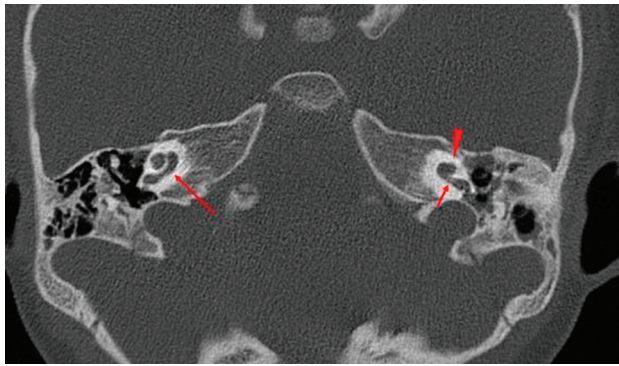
CT image of the patient with *SIX1*-BOR in whom the right cochlea does not demonstrate any offset (*long arrow*), while the left cochlea has an offset but with an appearance akin to cochlear hypoplasia type 4 rather than the typical unwound and offset cochlea of *EYA1*-BOR. Notice the normal size and morphology of the basal turn first half (*short arrow*), while the distal basal, middle, and apical turns are hypoplastic (*arrowhead*).
